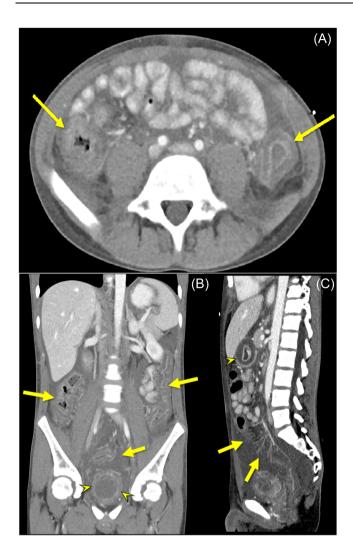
Axial, coronal, and sagittal contrast-enhanced CT images obtained as part of a work-up for abdominal symptoms. The CT image panels A–C here were obtained 7 days from the first admission due to worsening nausea and vomiting, and demonstrate significant disease advancement between scans. (A) Axial image at the level of the mid-abdomen shows severe wall thickening, mucosal, and serosal enhancement of the ascending and descending colon (arrows). (B) Coronal image showing wall thickening and mucosal and serosal enhancement in the ascending, descending, and sigmoid colon (arrows). Additionally, bladder wall thickening, and abnormal enhancement is present (arrowheads). (C) Sagittal midline image showing mesenteric hypervascularity—the comb sign—as another sign of bowel inflammation (arrows). Gastric antral thickening and hyperenhancement is seen in cross section (arrowhead). CT, computed tomography.
